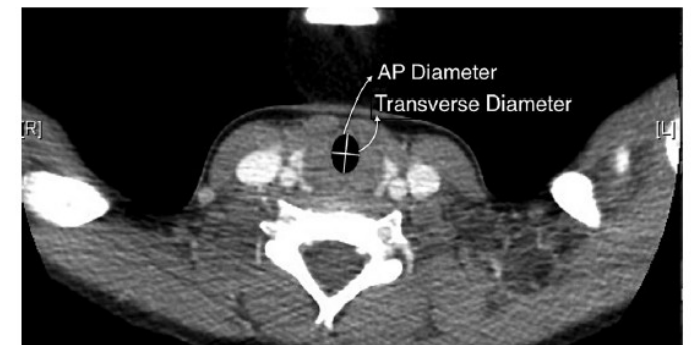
CT image of airway in transverse plane at subglottis.
